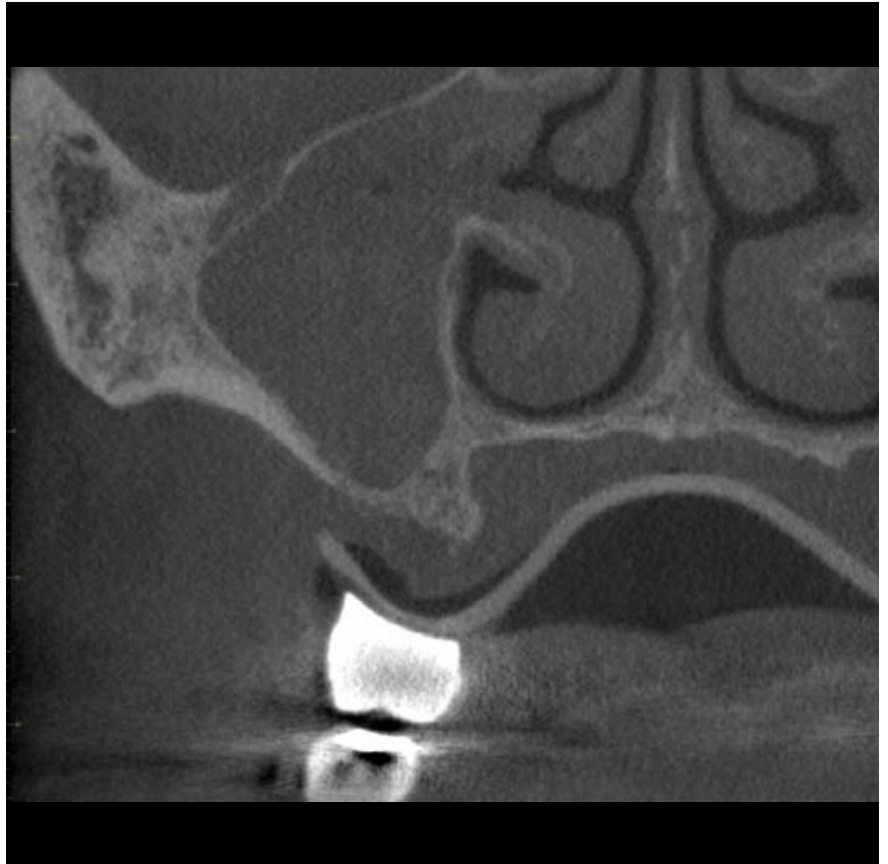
Coronal CBCT image, first molar region
